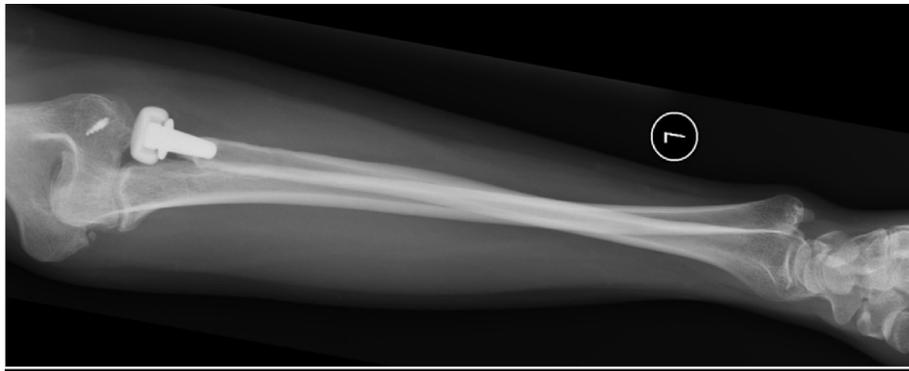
Lateral radiograph of left forearm. Patient presented with ongoing wrist pain after a radial head replacement for an acute fracture. Radiograph shows evidence of chronic distal radioulnar joint subluxation in keeping with an Essex-Lopresti injury.
